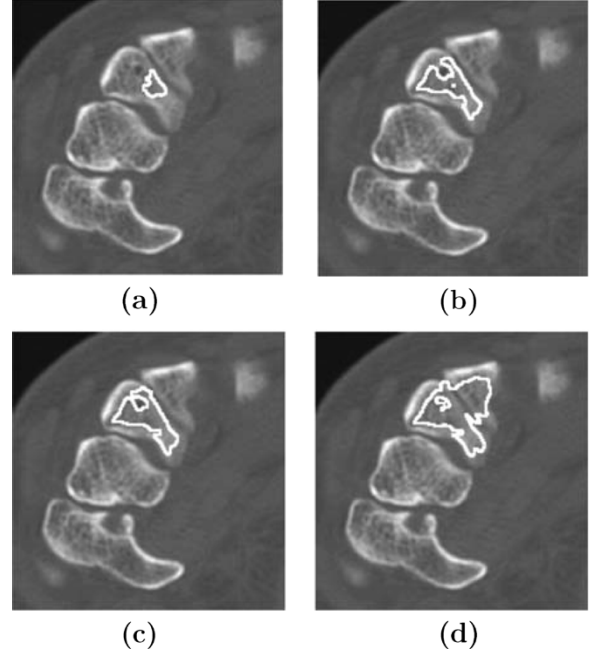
Examples to demonstrate the performance of Geodesic active contour level sets on a wrist CT slice. The superimposed white curves stand for the stable zero level set when σ is (a) 1.6, (b) 2.0, (c) 2.4, and (d) 2.5. It can be seen that when $\sigma \leq 2.4$, the zero level set can not reach the edge of the bone, and when $\sigma = 2.5$, the zero level set goes to another bone.
